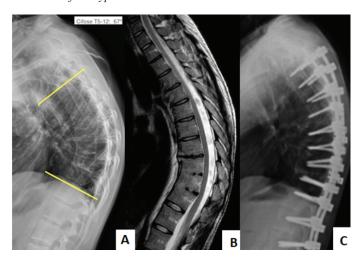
A – Preoperative lateral X-ray of the thoracic spine showing a 67° angle between T5 and T11. B – Preoperative MRI of the thoracic spine revealing multiple disc involvement and wedging of the vertebral bodies. C – Postoperative (6 months) lateral X-ray of the thoracic spine showing loosening of screws from T3 to T7 on the left side.
